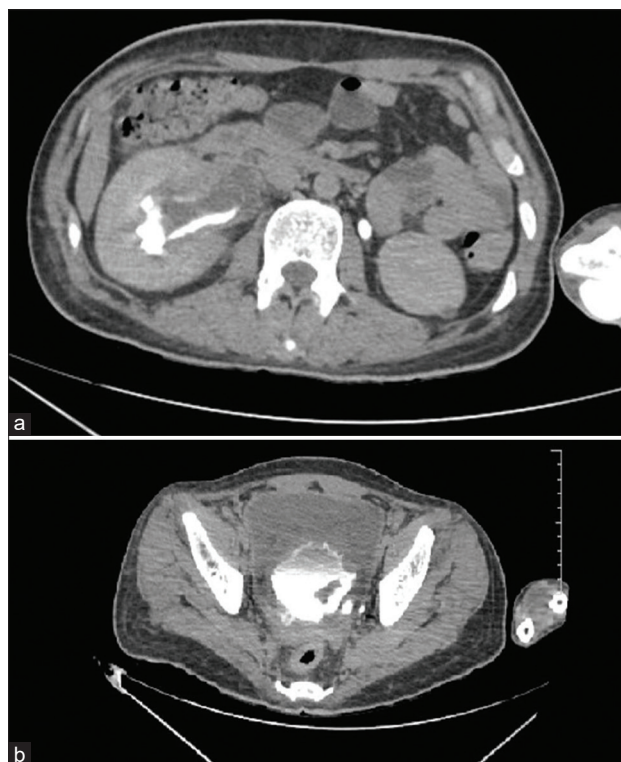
(a) Contrast computed tomography showing good contrast excretion in right kidney with filling defects in right pelvicalyceal. (b) Full bladder post bladder abscess drainage due to reformation of the abscess. The rim of calcification on the mucosal aspect due to calcium deposit on the necrotic mucosa seen
